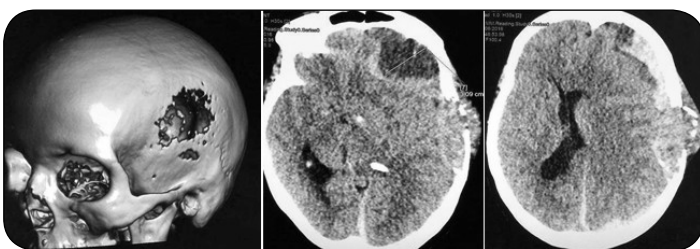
Cerebral CT scan showing voluminous left fronto-temporal osteolytic lesion with a significant mass effect with early temporal engagement.
